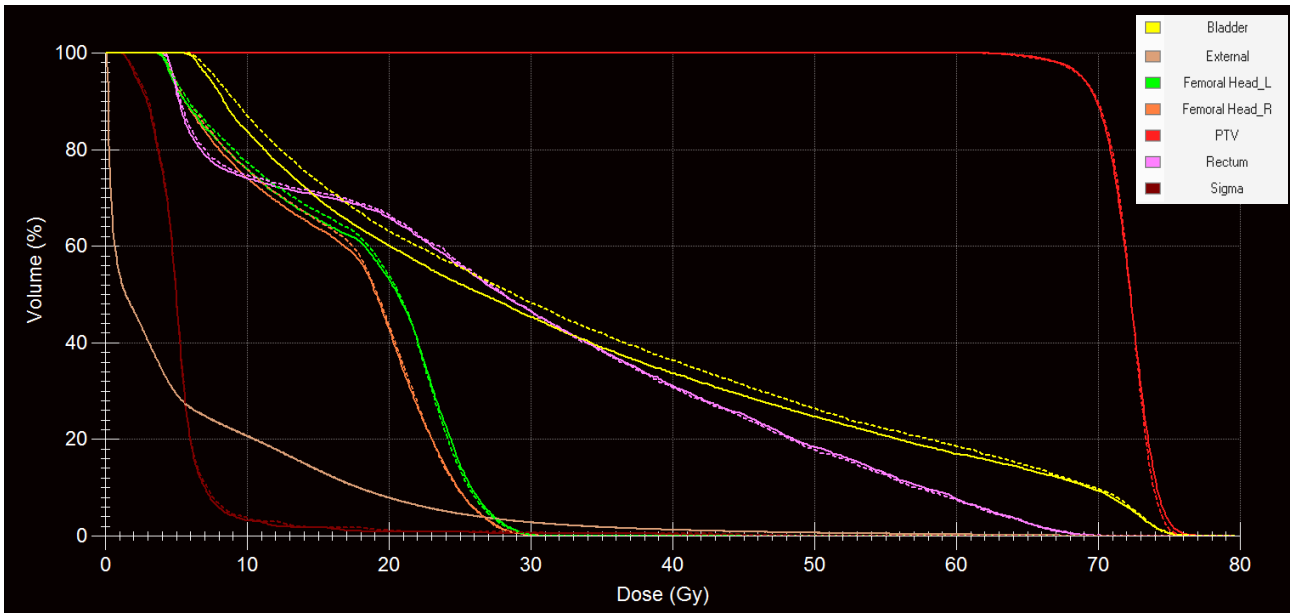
Example of DVH comparison between CT-based plan (continuous line) and sCT-based one (dashed line) reported in Fig. 22.
